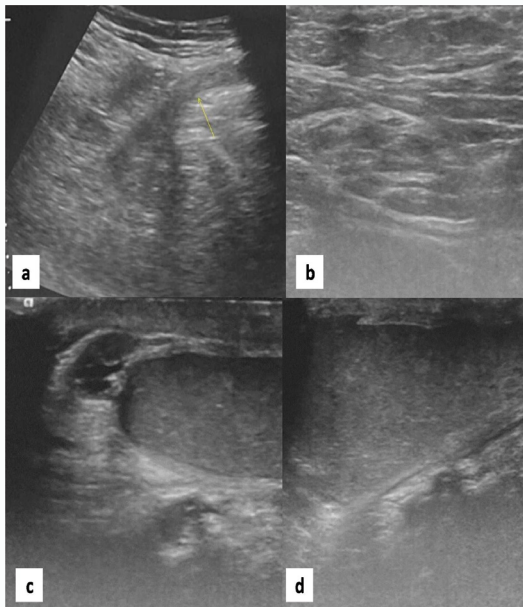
Ultrasound of inguinoscrotal region of 35 old male patient with TTE. USG image (a) showing left inguinal hernia (arrow). USG scrotum (b) showing empty right scrotal sac and bilateral testis in left scrotum (c, d).
